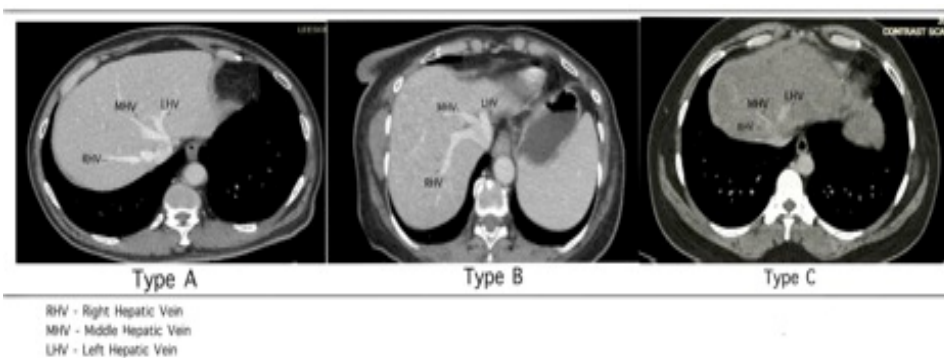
Images of CT scans of different MHV drainage
